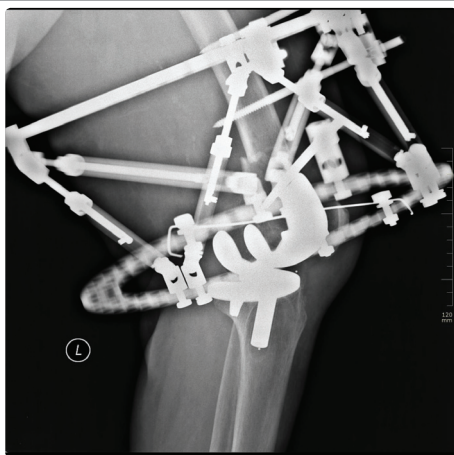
Radiograph showing the management of the fracture by computer assisted circular external fixation
